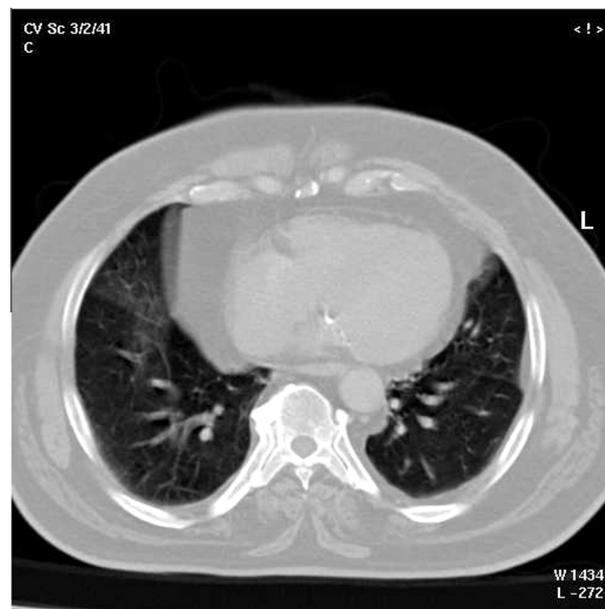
HRCT of lung window of lower lung zone in an early SLE patient revealed: ground glass appearance of anterior segment of right lower lobe.
